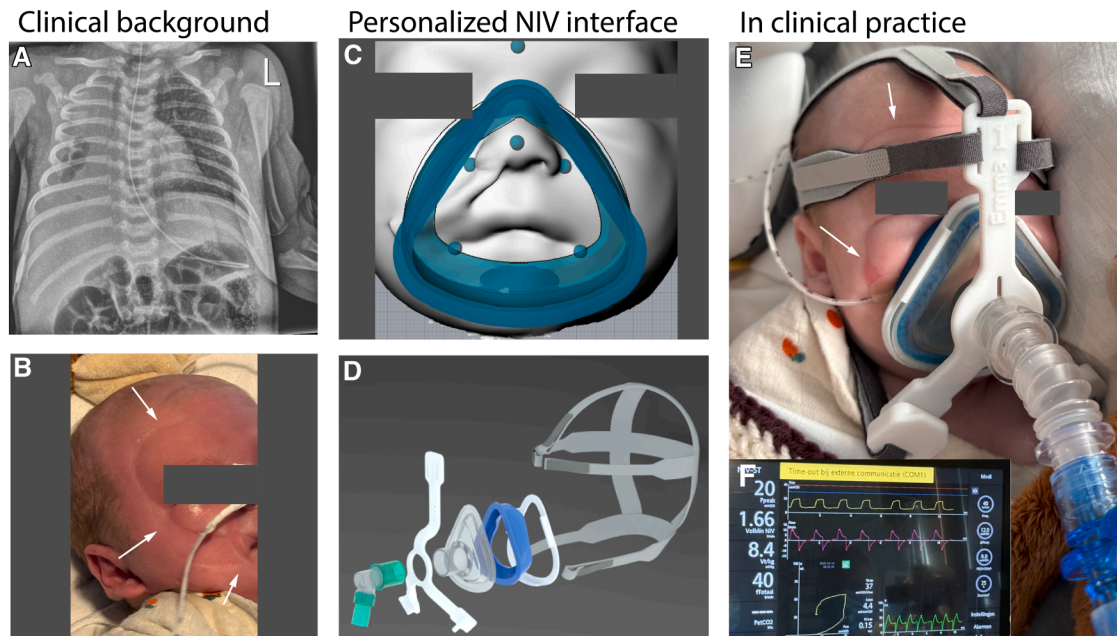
A, Radiograph of the chest showing complete right lung atelectasis and pneumatocele 1 day after extubation after a complicated course of invasive mechanical ventilation. B, Example of skin-pressure injuries (arrows) resulting from tightening a commercial total face mask to minimize air leaks during NIV. C, 3D-modeling of a personalized cushion for an oronasal NIV mask using semiautomated software (Rhinoceros plugin; nSize). D, A rendering of the fully 3D printed personalized oronasal NIV mask, which consists of a size-based mask with a frame (material: MED 9851; Henkel), frame ring, and holder (material: PC-ISO; Stratasys). The mask holder is attached to commercial headgear (Respireo SOFT from Air Liquide Healthcare) and placed around the mask to secure the mask to the face. In this size-based mask, a personalized, soft cushion is placed (material: MED 414; Henkel). E, A photograph, obtained with permission, of NIV treatment using the personalized oronasal NIV mask in the infant with postextubation acute respiratory failure. Arrows depict the skin-pressure injuries from the commercial total face mask that are still visible from its previous use. F, The ventilator mode was set on NIV Spontaneous/Timed, with positive end-expiratory pressure of 8 cmH₂O and peak inspiratory pressure of 20 cmH₂O.
